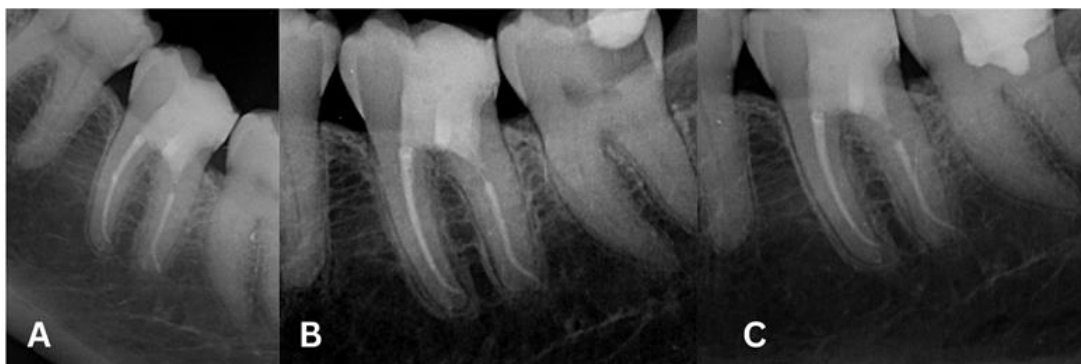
Case 2. (A) Post operative x-ray after restoring the tooth with fiber-reinforced resin. (B) Two years follow up. (C) Three years follow up
